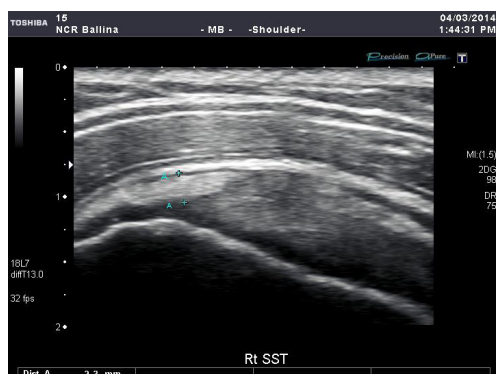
Subacromial bursitis. The image demonstrates a thickened bursa which is easily diagnosed on ultrasound.
